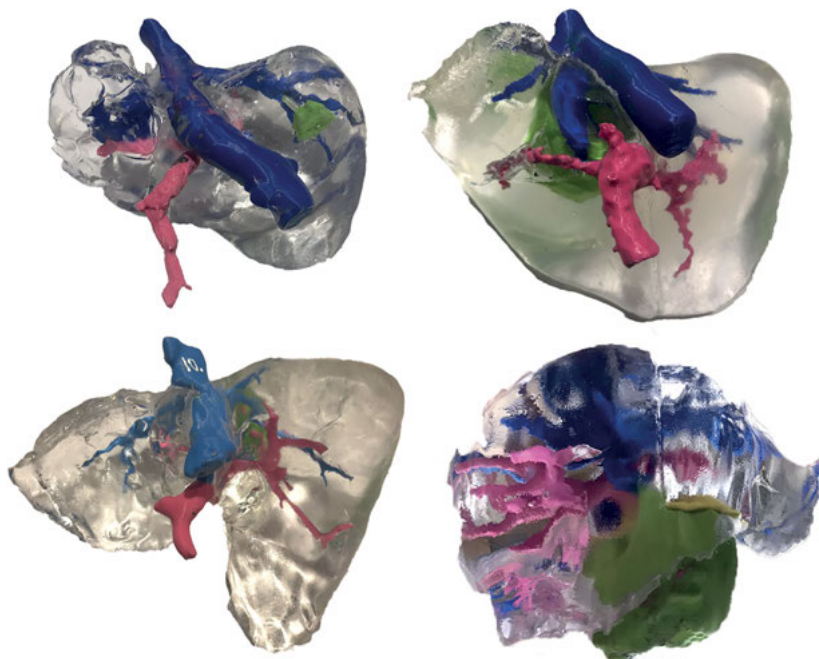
Examples of 3D liver models, developed routinely at Jagiellonian University (Kraków, Poland). They are fully personalized, full sized, and multimaterial. Our unique low-cost approach allowed to reduce production from approximately \$2,000 to \$150 per model. Average time from CT acquisition to model delivery is 5 days. Transparent parenchyma is made with silicone by casting it into a mold printed on a desktop FDM 3D printer.
